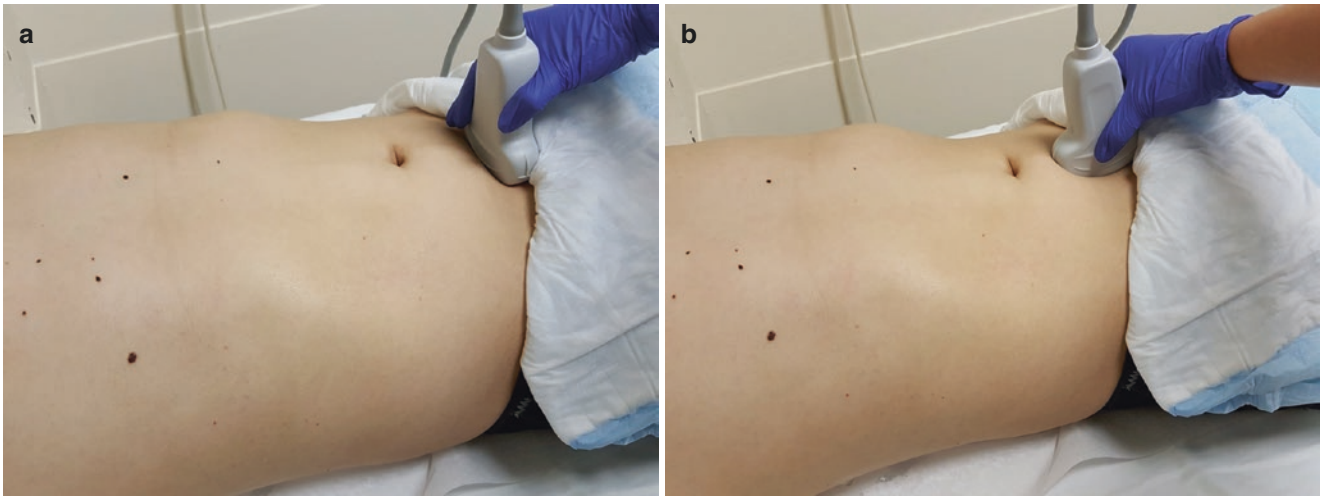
Ultrasound probe position for visualizing the pelvis. For a transverse view, the transducer should be placed in a transverse plane just superior to the pubic symphysis with the transducer marker pointed
